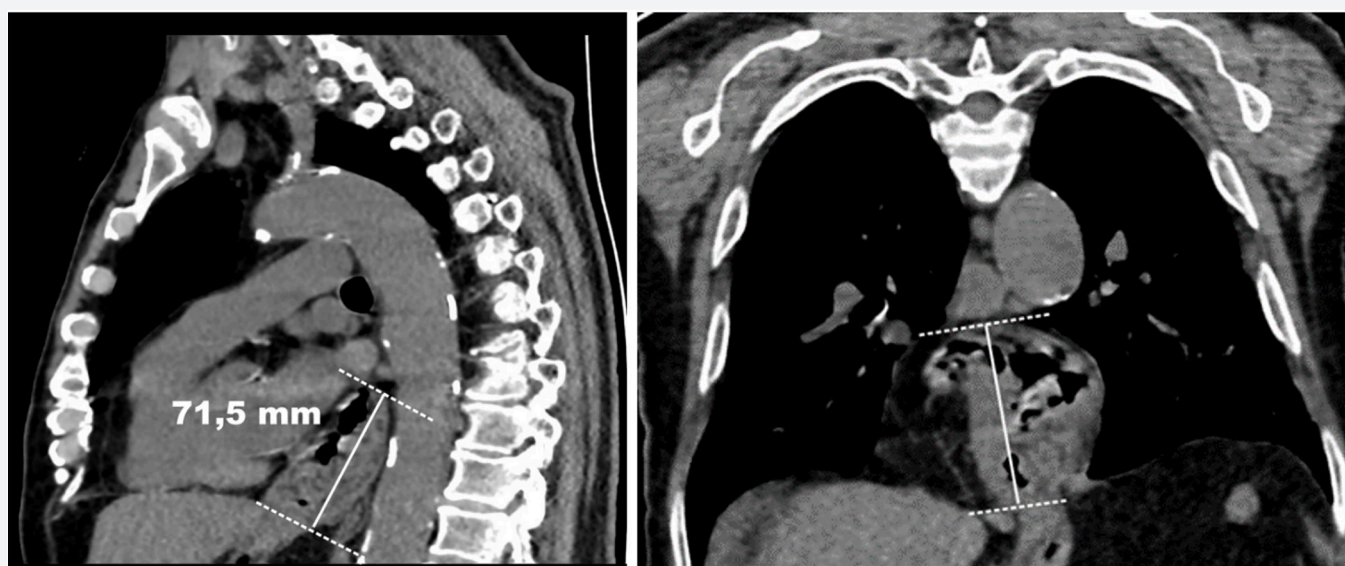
Sagittal (a) and coronal (b) computed tomography scan of a 75-year-old male patient with a hiatal hernia. The length of the hernia was measured (straight line) from the level of the esophageal hiatus (dashed line) to the upper direction of the contour change (dashed line)
